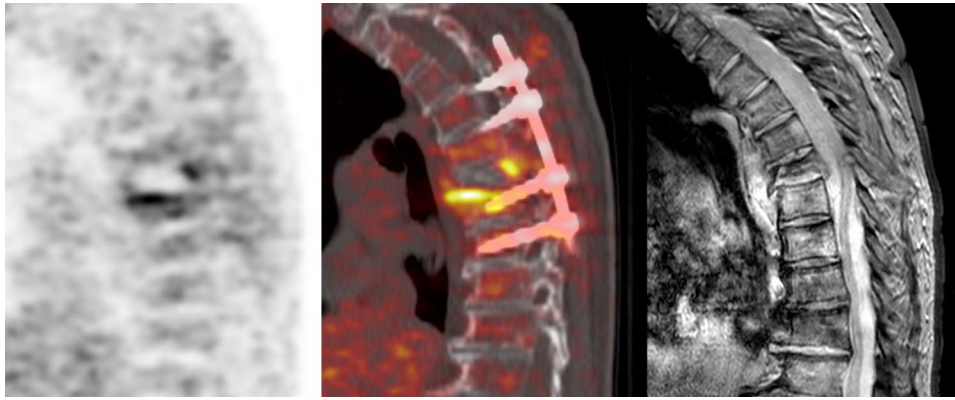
Spondylodiscitis in postoperative patient. An 82-year old woman with diabetes mellitus presents with progressive paresis of both legs, starting the day before. MR imaging shows collapse of vertebra Th7 with an epidural mass and compression on the spinal cord (sagittal T1-weighted gadolinium-enhanced image at right panel). Laminectomy Th7 with posterior fixation of levels Th5 through Th9
